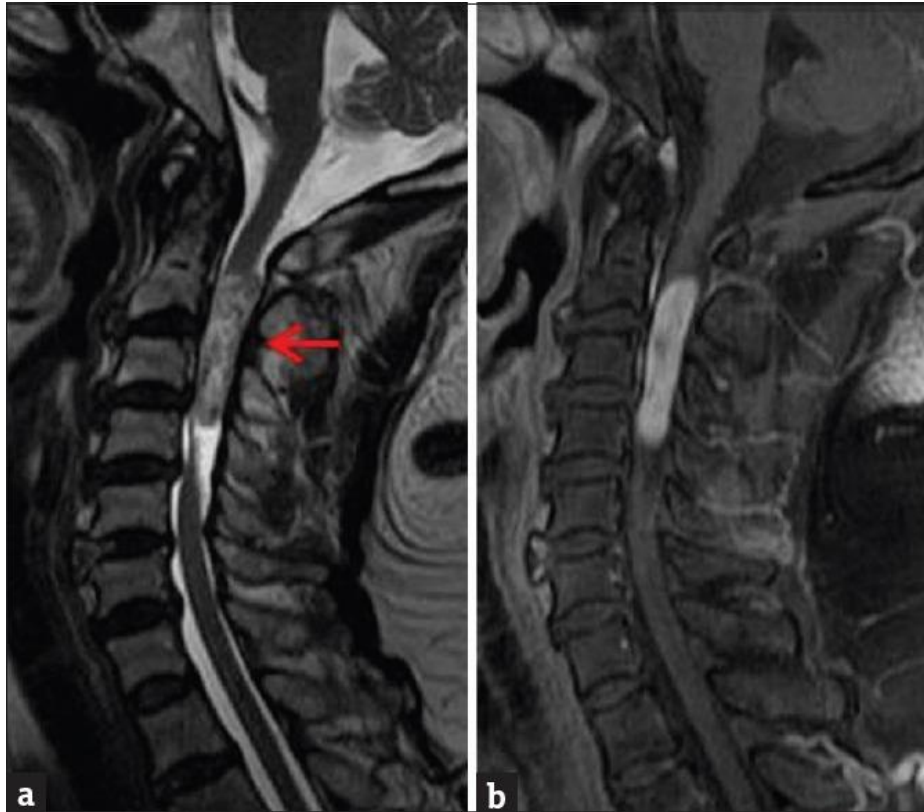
MRI cervical spine magnetic resonance imaging (a) Sagittal T2-weighted sequence demonstrates heterogeneously T2 hyperintense intramedullary mass extending from C2-C4 spinal segments. (b) Enhanced T1-weighted sequence demonstrates nearly homogeneous mass enhancement. Pathology was consistent with schwannoma.
